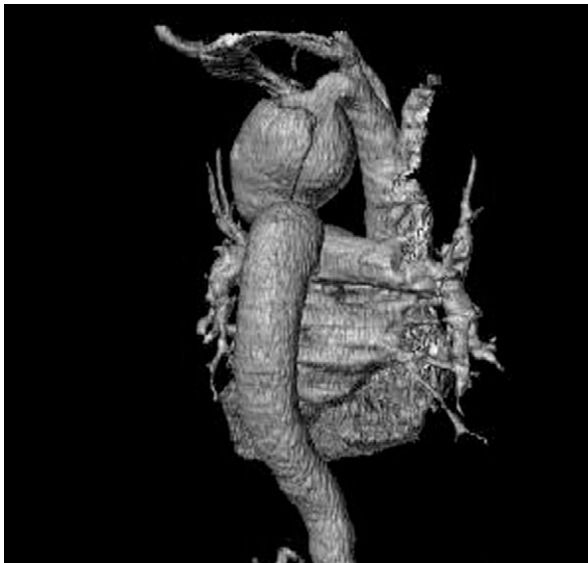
Preoperative computed tomogram (3-dimensional volume-rendered reconstruction) of the thoracic aorta shows the dissected aneurysm.
